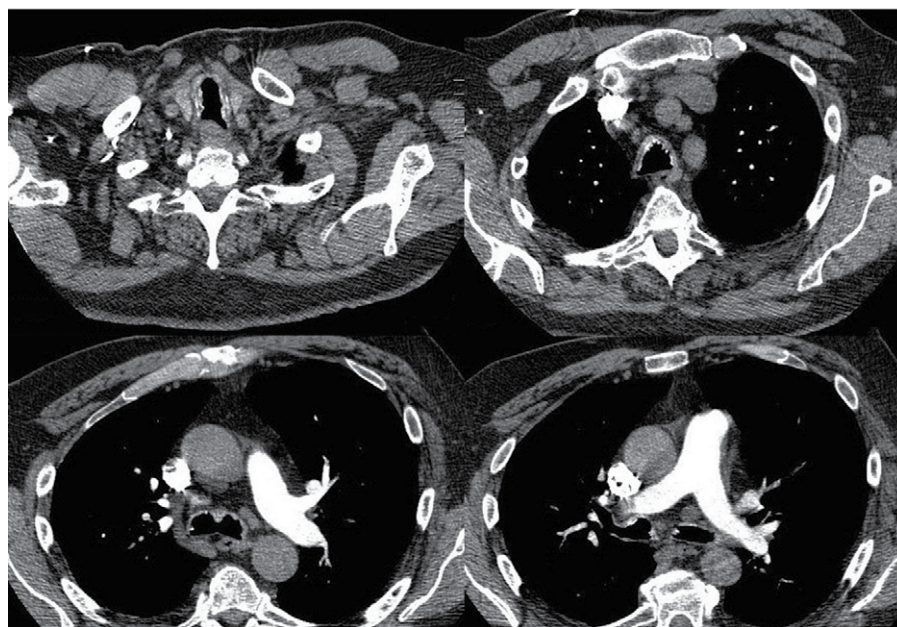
Chest CT scan showing multiple parietal calcifications and intraluminal nodular protrusions in the trachea and main bronchi, sparing the posterior membrane.
